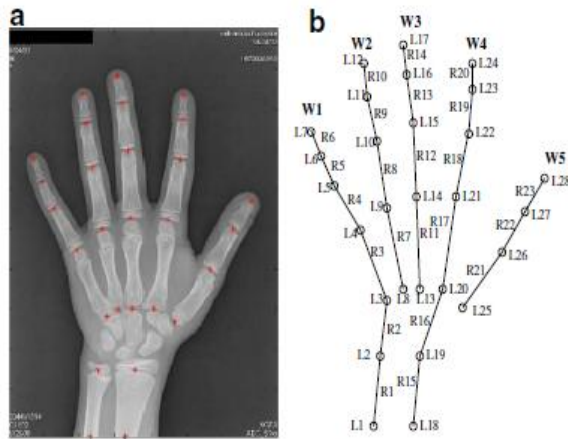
a) Landmarks marked in the radiography of hand; b) Scheme of landmark selection that constructs the wire model in the realistic way. (Taken from [42])
